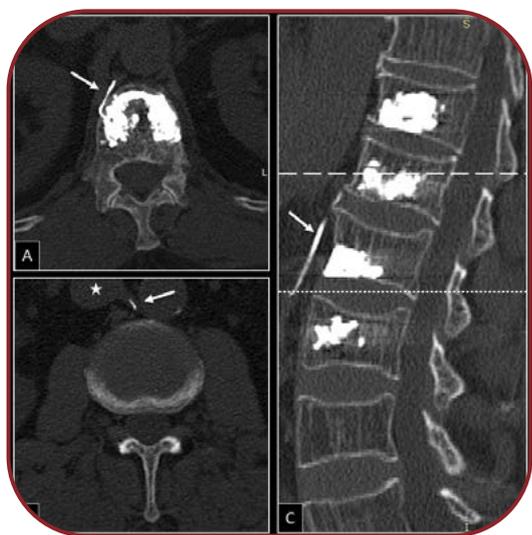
(A) Axial lumbar spine CT image (at the level indicated by the white long-dashed line seen in part C of the figure) and (B) axial lumbar spine CT image at a more caudal level (indicated by the white round-dotted line seen in part C of the figure), display retrograde cement leakage (white arrows) into the Batson's paravertebral vein, caudally directed towards the inferior vena cava (white asterisk)
